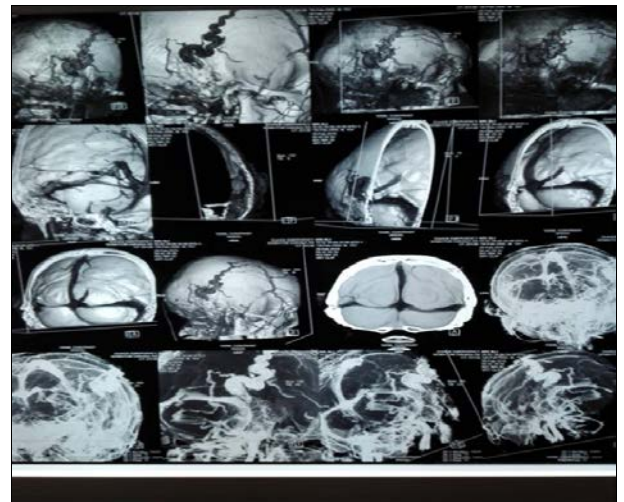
CT angiography digital subtraction angiography (DSA).
